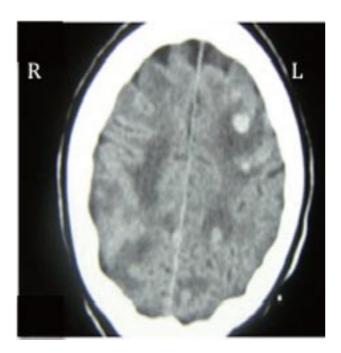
Computed tomography shows hyperdense scolices in the brain parenchyma (left fontal lobe++) surrounding with perilesional oedema.
